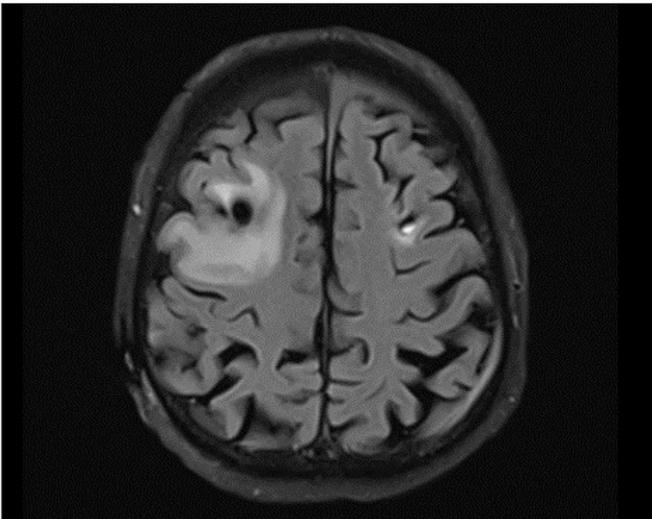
T2 Flair MRI showing large edema surrounding the right electrode.
